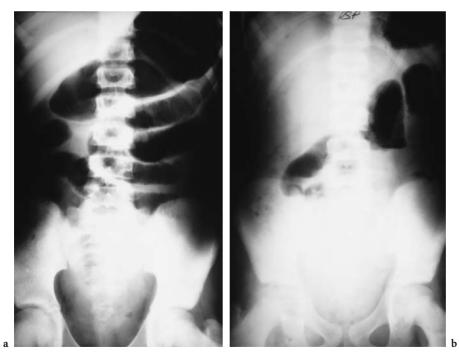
Small bowel obstruction due to adhesive band. a Supine plain radiograph shows multiple dilated loops of proximal small bowel. b Erect film demonstrates multiple air-fluid levels
